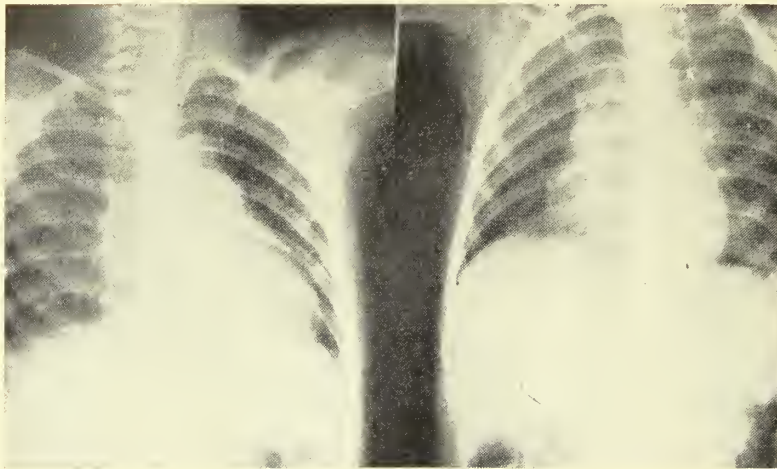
Left: Peanut in left bronchus—36 hours' duration. Roentgenogram shows an atelectasis of left lung. Right: After-ray, 24 hours later, shows left lung re-expanded and mediastinal structures back in normal position.
